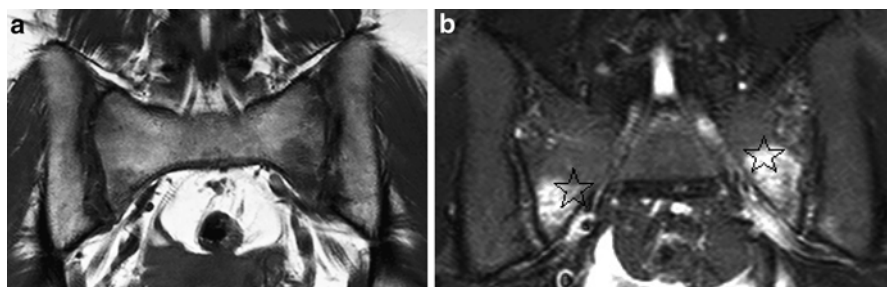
A 29-year-old woman, 3 months postpartum vacuum-assisted vaginal delivery presenting with pelvic girdle pain syndrome and known pubic diastasis. MRI imaging of the sacrum and SI joints with (a) axial T1 sequence and (b) axial T2 fat saturation sequence show how bilateral bone stress injuries (*star*) of the sacral ala as best demonstrated on fluid-sensitive sequence (b)
